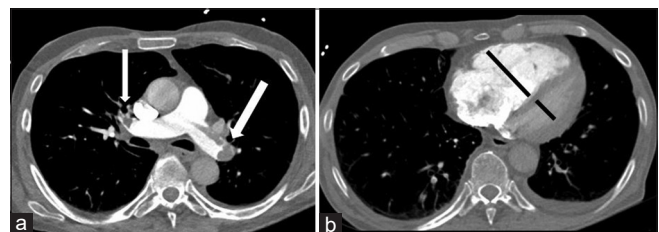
(a and b) Acute bilateral PE. Axial contrast enhanced computed tomography scan showing filling defects (a) in both pulmonary arteries left > right (solid white arrows). The same patient with right heart strain (b) with the right ventricle twice the size of the left (black solid lines)
